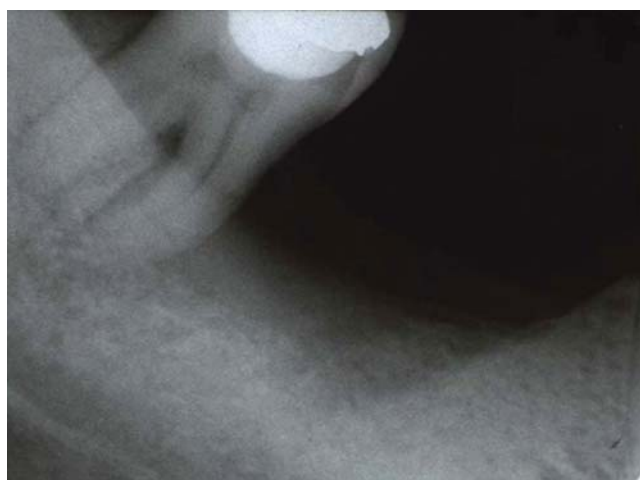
The preoperative radiograph revealed a deep intrabony defect and a resorbed alveolar ridge
